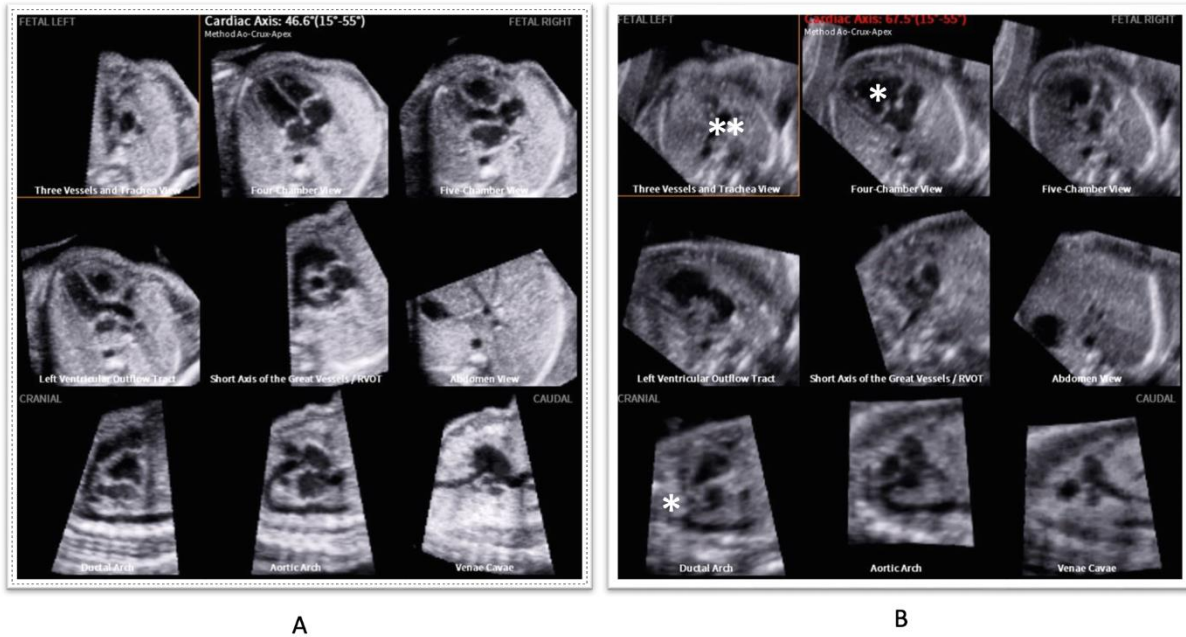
Fetal Intelligent Navigation Echocardiography (FINE) (Abbildungen von der Autorin). A: Aufnahme eines unauffälligen fetalen Herzens mit neun Standardebenen (von links oben nach rechts: Dreigeäßblick, Vierkammerblick, Fünfkammerblick, linksventrikulärer Ausflusstrakt, kurze Achse der großen Gefäße, Abdomen, Duktusbogen, Aortenbogen, bikavale Ansicht). Die Herzachse ist bei 46,6° im normalen Range. B: Echokardiographie bei einem Feten mit Double Inlet Left Ventricle (DILV) und Pulmonalatresie. Der Dreigeäßblick weist in diesem Fall nur zwei große Gefäße auf (*Aorta und *Vena cava superior), der Vierkammerblick und der linksventrikuläre Ausflusstrakt deuten auf die *Abwesenheit des Ventrikelseptums hin, bei der Aufnahme des Duktusbogens fällt die *Pulmonalatresie auf.
